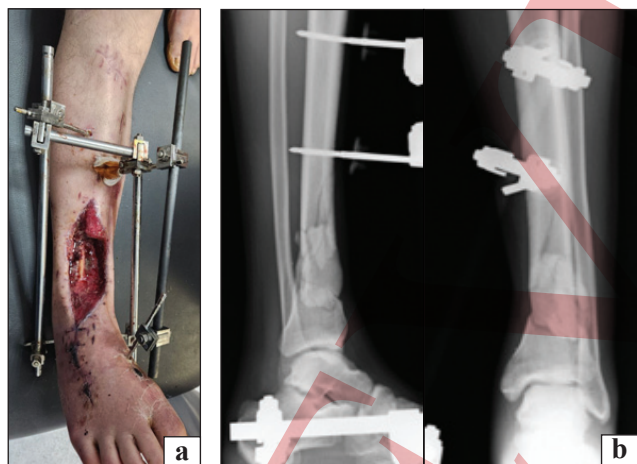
Photo of the injury upon hospitalization (a); radiographic image of the patient at the time of hospitalization (b)
